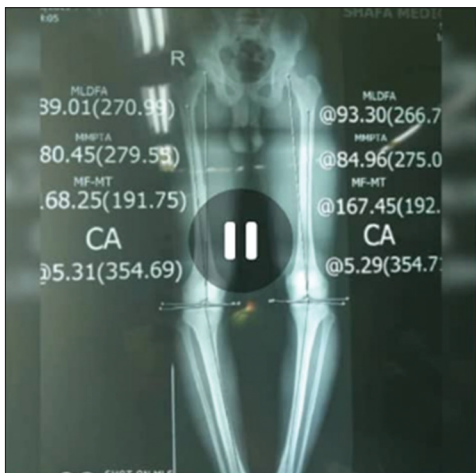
The alignment view radiography before surgical procedure representing medial proximal tibial angle of 80° and 84° in right and left sides, respectively
